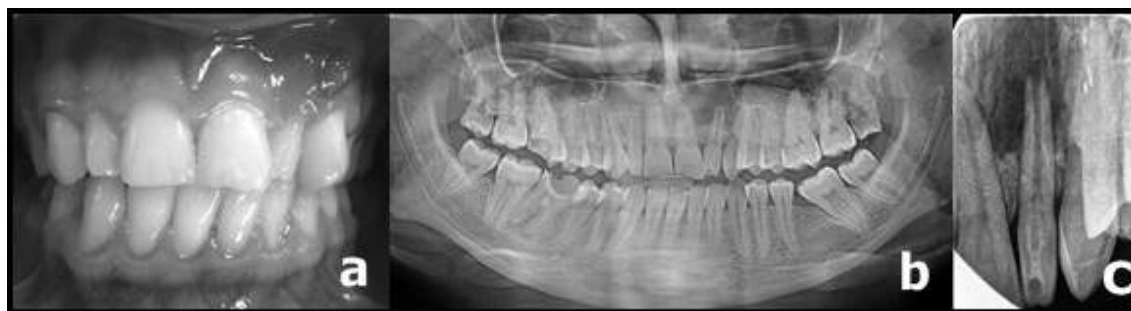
(a) Photograph shows that maxillary left incisor has a sinus tract, (b) panoramic radiograph shows that the contralateral tooth did not reveal malformation, (c) periapical radiography shows that a dens invagination and periradicular lesion
